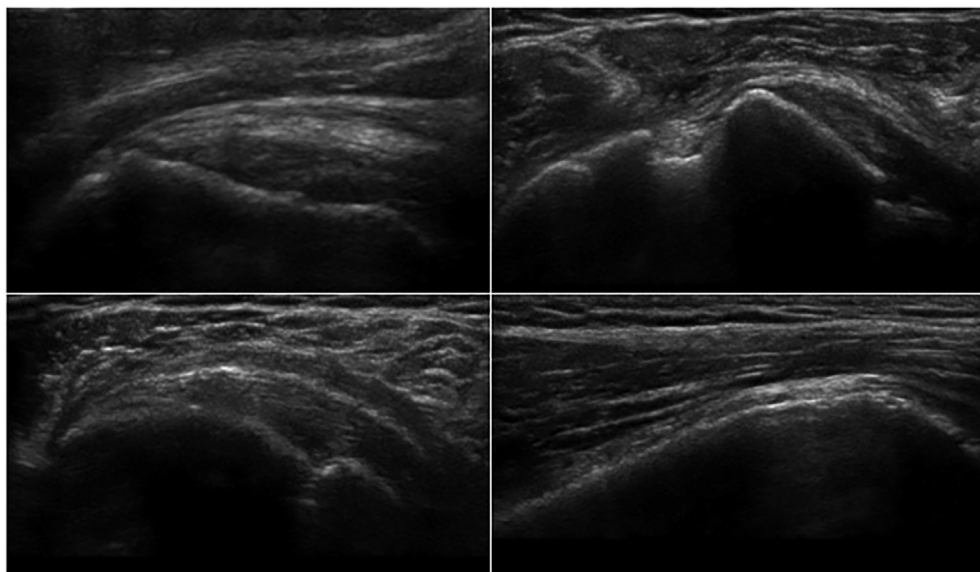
Ultrasonography (intact tenodesis and rotator cuff repair).
